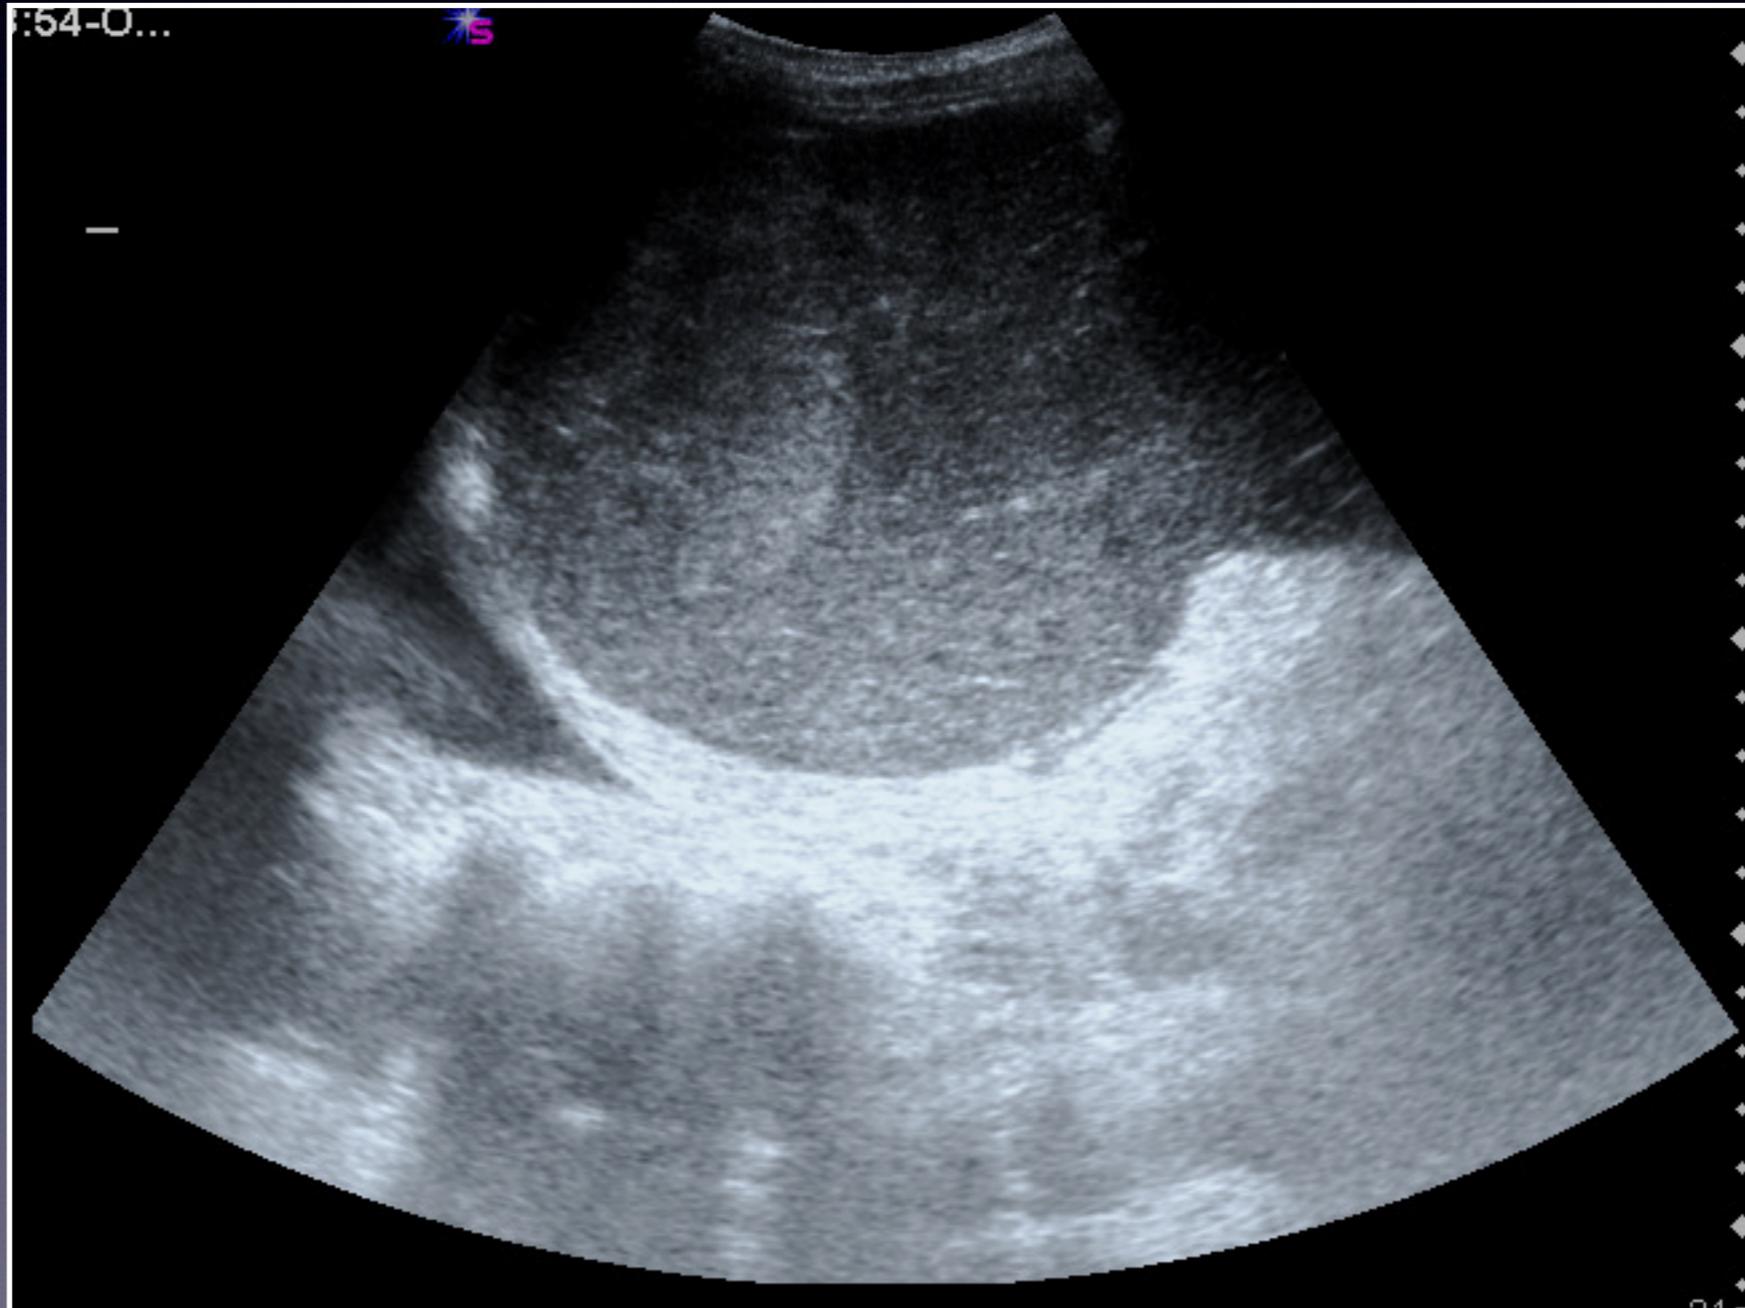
Splenic infarct. a) sonogram shows a triangular hypoechoic lesion (asterisk); b) CEUS, arterial time – the splenic lesion is unenhanced; c) CEUS, parenchymal phase – the lesion presents no enhancement (S = spleen; R = left kidney).
